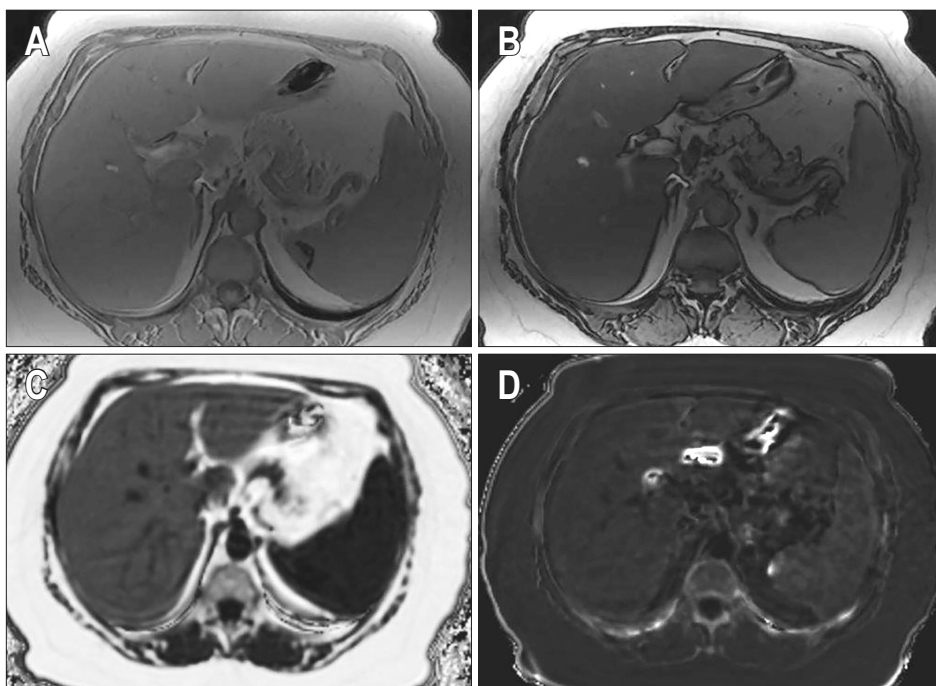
Chemical shift encoded magnetic resonance images of a patient with severe hepatic steatosis. In-phase (A) and out-of-phase (B) images show diffuse loss of signal in the liver on out-of-phase image compared to the in-phase image, which is consistent with hepatic steatosis. Corrected proton density fat fraction (PDFF) (C) and $R2^*$ maps (D) are also shown at the bottom. The patient had a mean PDFF of 20%.
